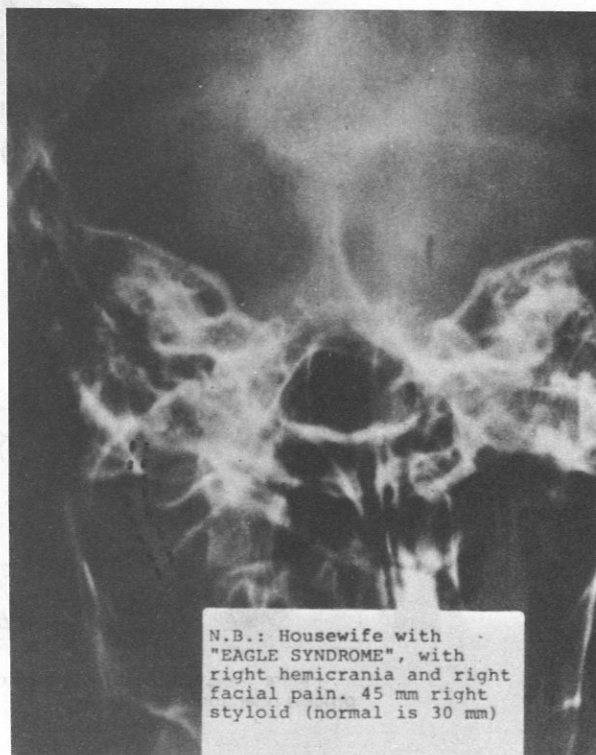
Townes-view X-ray study reveals enlarged styloid process on the left (dotted lines), angulating medially to impinge on the carotid sheath.
